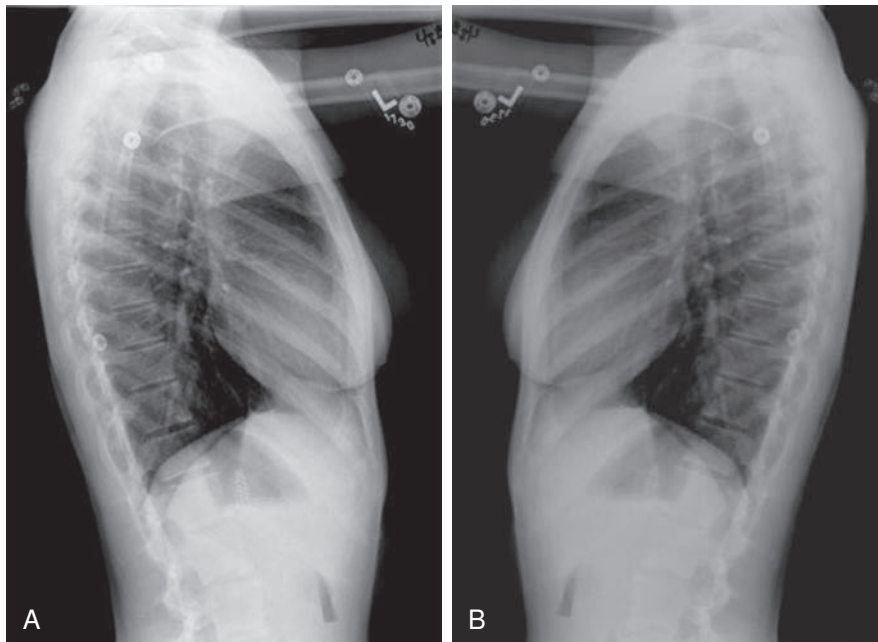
Reorienting an Image. Postprocessing software allows for image rotation, flipping, and reorientation. (A) A left lateral chest x-ray was taken and then (B) was flipped to correctly display for radiologist reading protocol.
